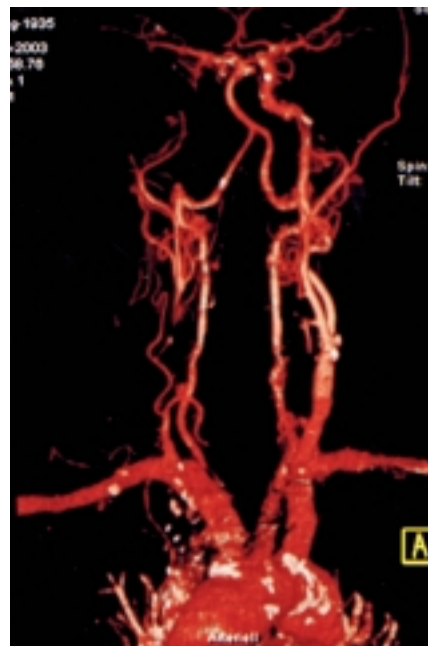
Supra-aortic CT angiography of a 69-year-old patient with recurrent episodes of left transient ischemic attacks. CTA (40 ml Iomeron 400) depicts right common and internal carotid artery occlusion. Collateral filling of the external carotid artery is via the right vertebral artery. The left internal carotid artery is narrowed distal to an ulceration and a calcified plaque at the origin. Additionally a stenosis is present within the cervical segment of the left vertebral artery
